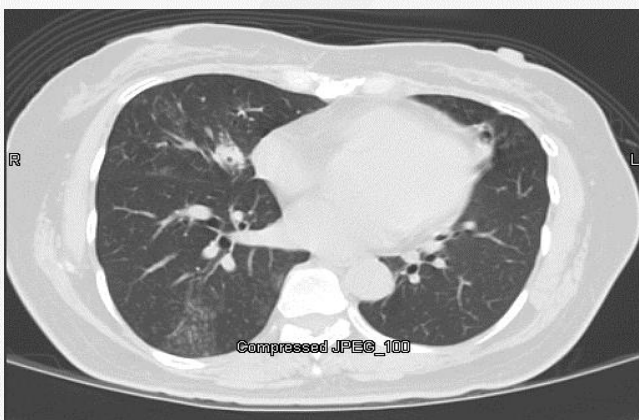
Repeat HRCT of the chest revealing centrilobular nodules/ ground glass densities in the right lower lobe and posterior right upper lobe (arrows) suggestive of endobronchial spread of infection and/or bronchiolitis.
